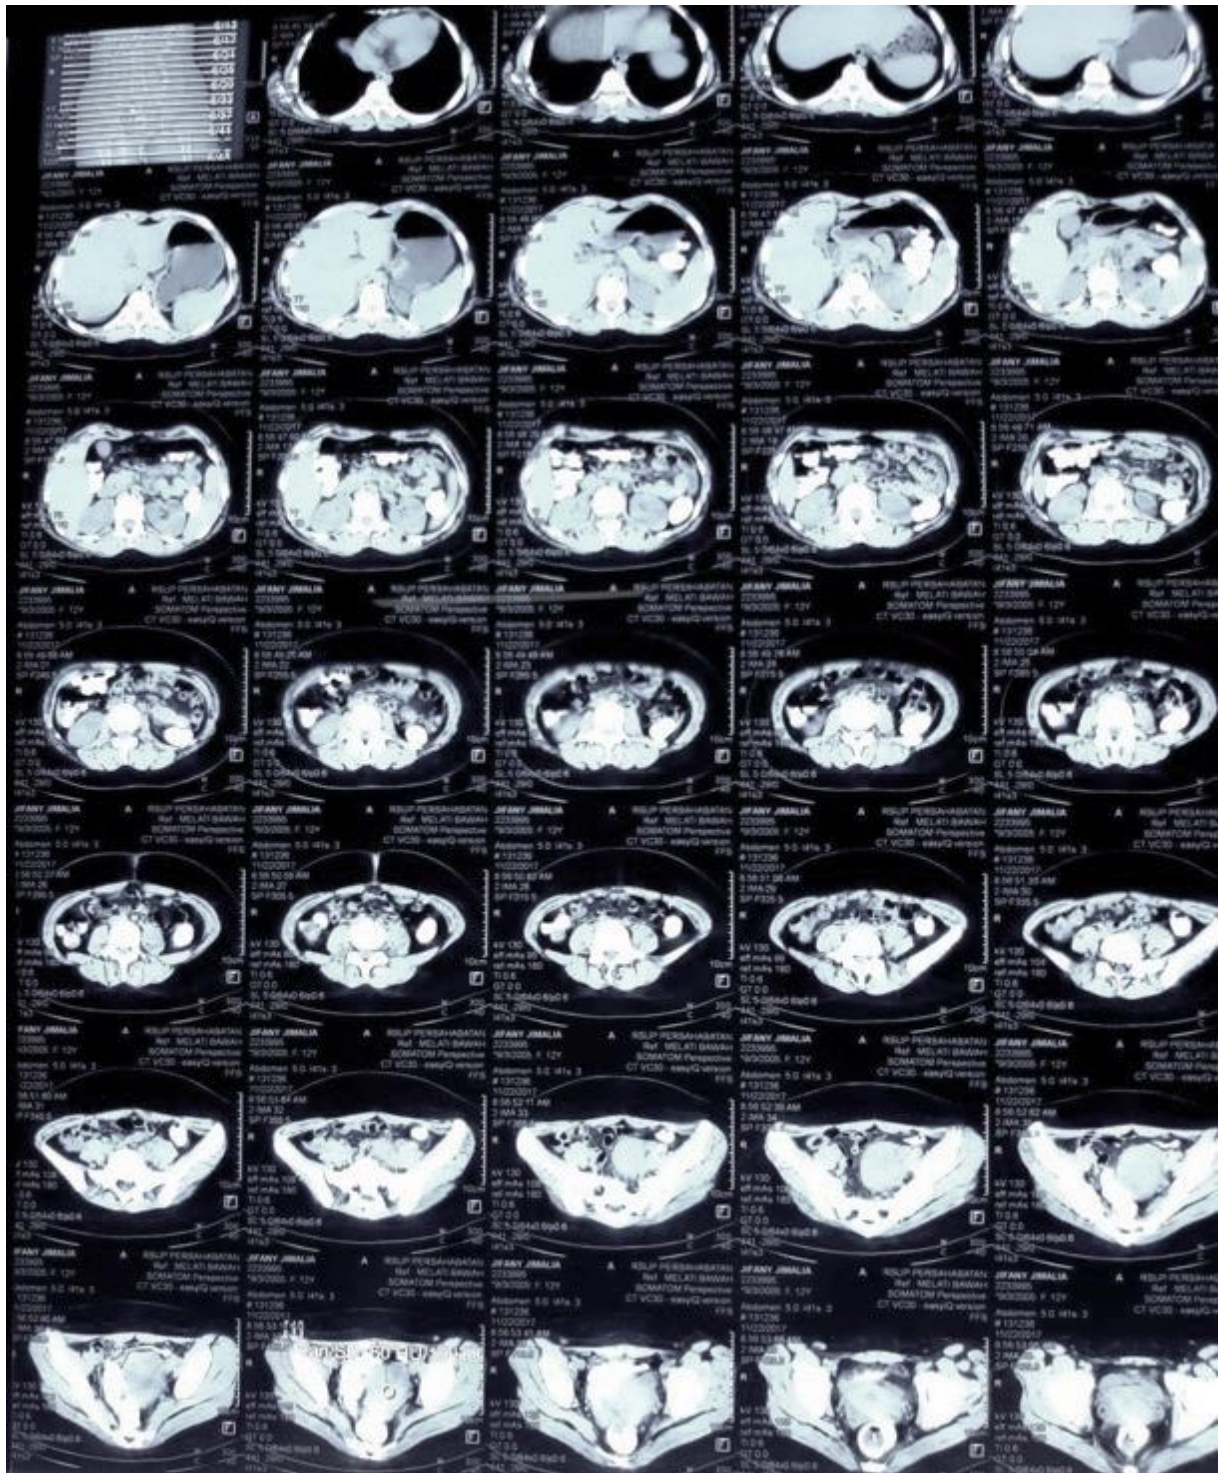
Axial sections of contrast CT scan.
